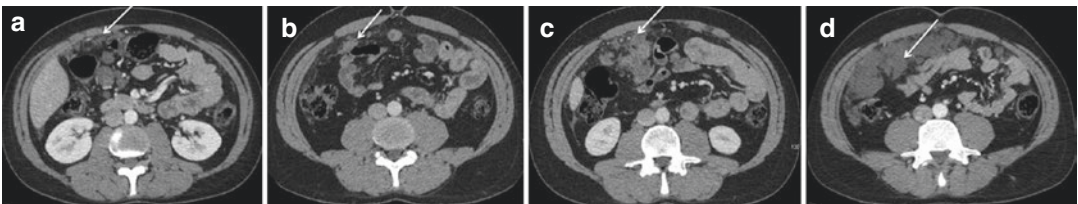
Axial contrast-enhanced CT images show various morphologic patterns of peritoneal carcinomatosis ranging from very subtle disease to bulky infiltration in four patients
